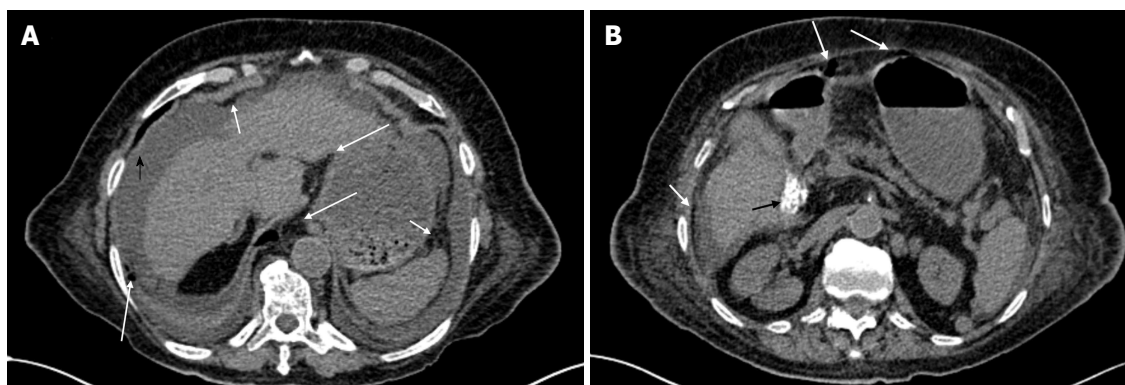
CT scan findings. A: Evidence of an important abdominopelvic peritoneal effusion (black arrowhead), perigastric free air along the gastrocolic ligament and under the anterior abdominal wall (white arrows), and pericardial and bilateral pleural effusions; B: In addition to perigastric free air and under the abdominal wall (white arrows), a microlithiasis (black arrow) of the gallbladder could also be observed.
